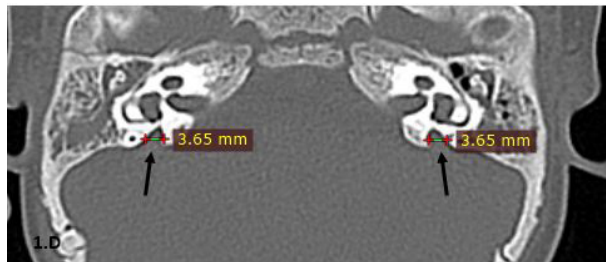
D: Axial CT bone window revealed bilateral dilated vestibular aqueducts (black arrows). Normal diameter less than 1.5 mm.
